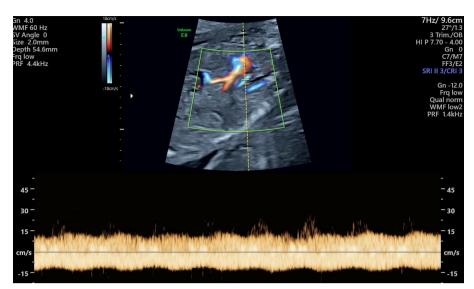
Fetal ultrasound image showing an abnormal vessel with typical venous flow of blood – no increased velocity until the 37th week of pregnancy. Ultrasound image from examination at 21.3 weeks of gestation
